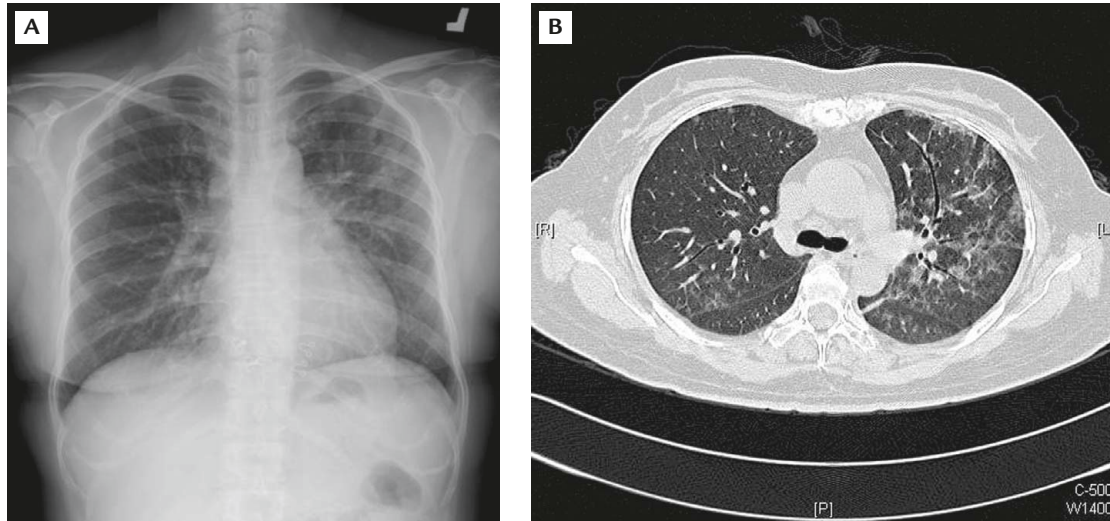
(A) Chest X-ray of Case 2 shows ground glass appearance in the left lung field. (B) High-resolution computed tomography reveals slight thickening of the interlobular septa and intralobular interstitium in the left lung with multifocal ground glass opacities.
